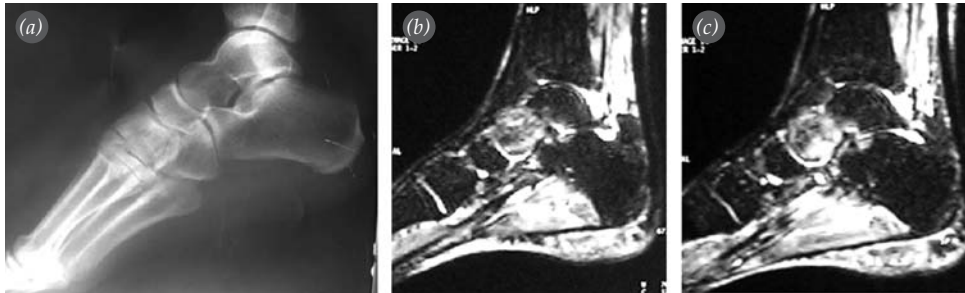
(a) Initial lateral radiograph and (b, c) sagittal T2-weighted MR imaging of missed talar neck fractures in ankle distortions.
